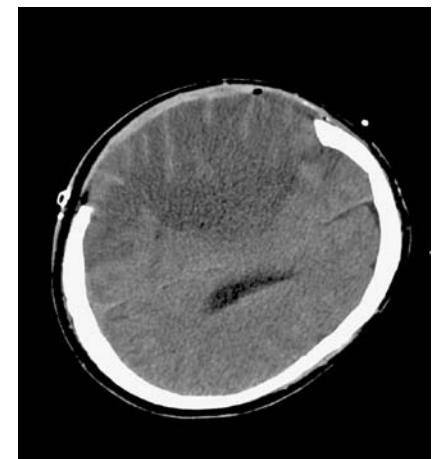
Computed tomography head scan showing changes following craniectomy. The patient survived and now does standing transfers independently six months after surgery.
